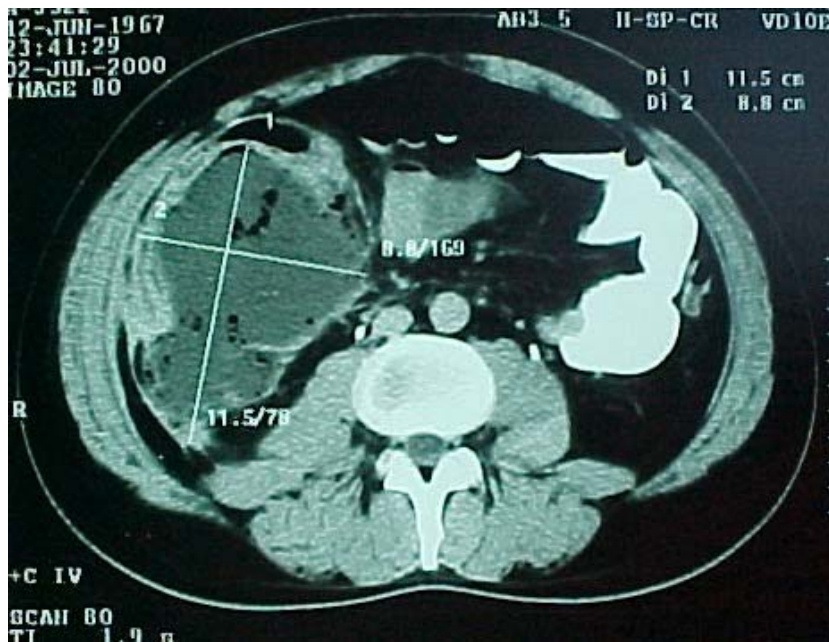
Appendix abscess on CT scan
